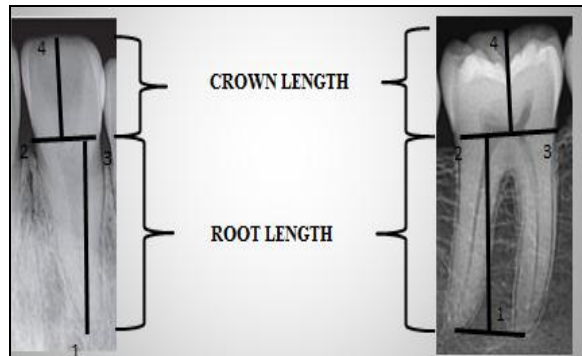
Reference lines and points are according to the study of Linge and Linge.¹¹ A line was marked from point 2 to 3 representing the CEJ, which is the anatomical junction between the crown and root of the tooth. For multi-rooted teeth another line was marked on orthopantomogram connecting the root apices. To measure the crown height a perpendicular is dropped from the top most of the crown point 4 to the CEJ. Similarly to measure the root length a perpendicular is dropped from the CEJ to the root apex or in the center of the line joining the root apices in case of multi rooted tooth demarcated as point 1
